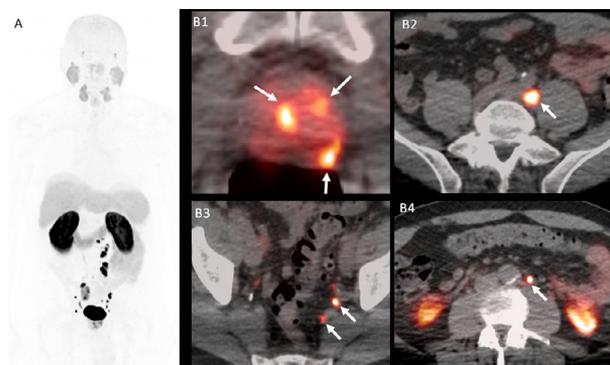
^{18}F -DCFPyL PET/CT in a patient recently diagnosed of high-risk primary prostate cancer. A 66-year-old man with biopsy-proven adenocarcinoma of the prostate, Gleason 9 (4+5) and PSA of 7.1 ng/mL. Maximal intensity projection (A), and axial fused ^{18}F -DCFPyL PET/CT images (B) demonstrate multiple DCFPyL-avid foci at the prostate gland (B1), and additional multiple DCFPyL-avid bilateral pelvic (A, B2, and B3) and left retroperitoneal lymph nodes (A and B4).
